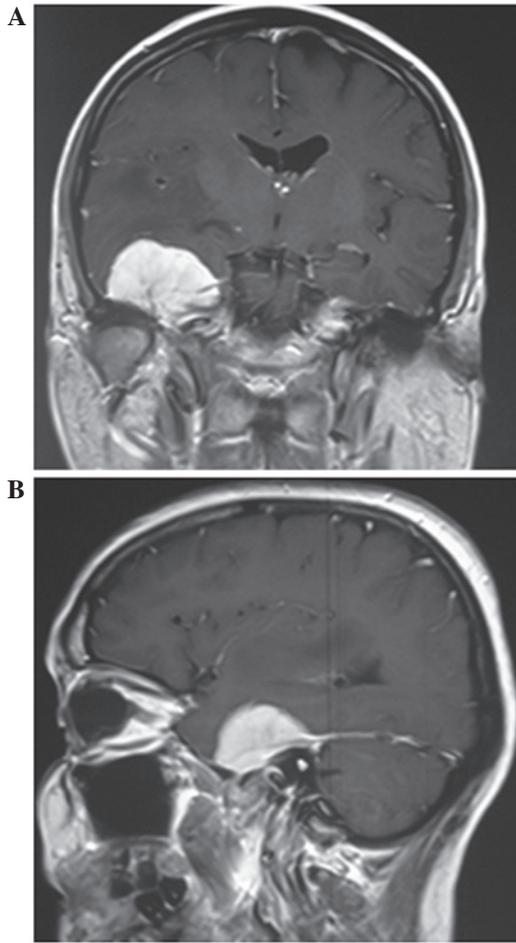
(A) Coronal and (B) sagittal brain magnetic resonance imaging with gadolinium performed in July 2004 revealing a right temporal mass widely involving the middle cranial fossa.
